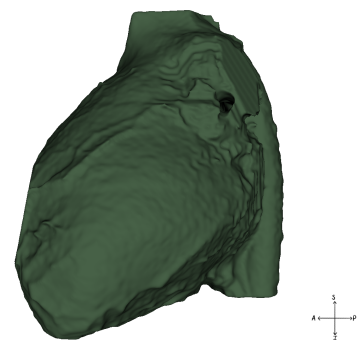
Result of the segmentation made with the CT scan of the heart of the patient with ToF. Left section of the hollow model where the green structure represents the soft tissue. Left view.
